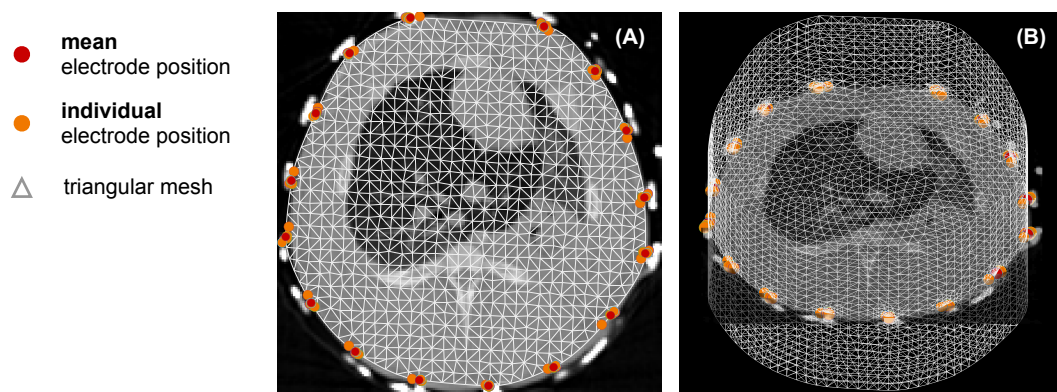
Exemplary created reconstruction models used for EIT reconstruction during the analysis of the Dresden study. Image (A) depicts the CT image within the electrode belt level. The individual electrode and joint electrode positions as well as the triangulated 2D reconstruction mesh is shown. The 2D reconstruction model was used for all algorithms. Besides the GREIT reconstruction, the 2D-mesh was also used for the forward calculation. For the GREIT reconstruction, a 2.5D mesh was used for forward calculation as depicted in image (B). The 2D torso surface was herefore extruded.
